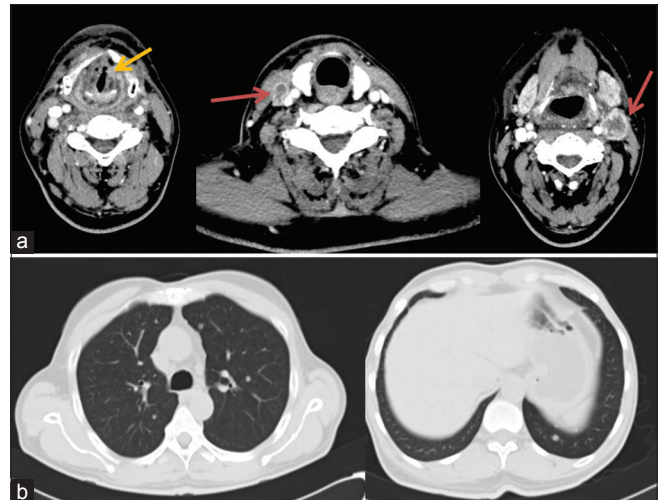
Contrast-enhanced computed tomography of the neck and thorax. Transaxial slices reveal ill-defined enhancing lesion in the area of false vocal cord on the left side (yellow arrow, a). Multiple heterogeneously enhancing bilateral cervical lymph nodes with likely necrotic areas within them are seen (red arrows, a). Multiple lung nodules are also seen in both the lungs (b)
